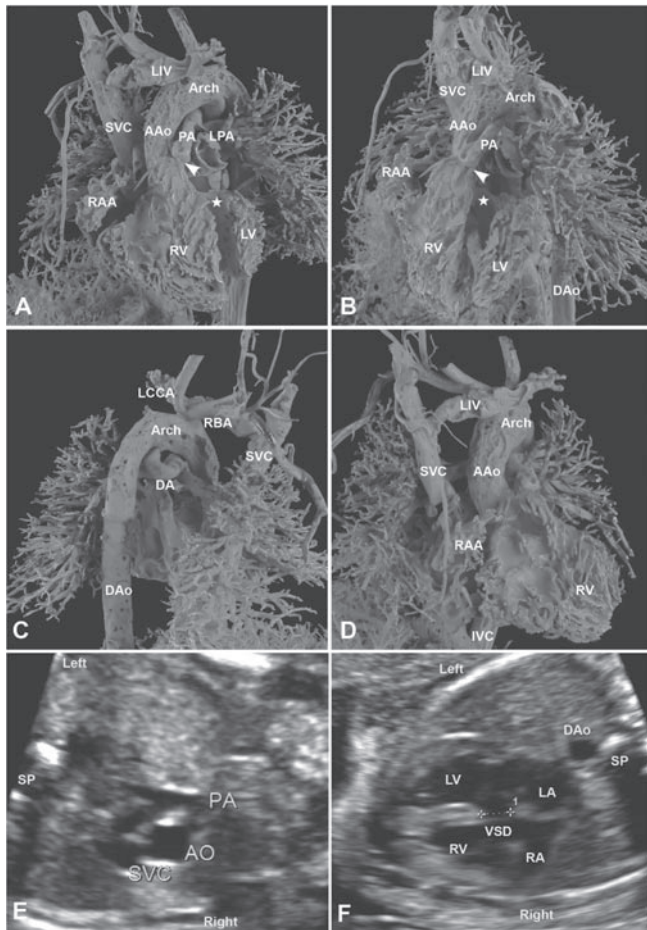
Cast demonstration of a fetus with hypoplastic left heart syndrome (HLHS), double outlet right ventricle (DORV), pulmonary valve atresia (PVA), pulmonary artery stenosis (PAS), ventricular septal defect (VSD), etc. (case 10). (A) Left anterior 30° view: AAo and PA are both originated from RV. A disconnection between RV and PA indicates the pulmonary valve atresia (white arrowhead). (B) Left anterior 45° view: Pulmonary trunk and left/right pulmonary artery are narrowed. An abnormal connection between RV and hypoplastic LV suggests a ventricular septal defect (white asterisk). (C) Right posterior 45° view: A tortuous DA connects PA and DAo. RBA and LCCA have a common trunk in the initial segment. (D) Right side view: Dilated AO anomalously originated from RV. (E) Prenatal echocardiography showed pulmonary stenosis. (F) A large VSD was showed in the prenatal sonography. AAo, ascending aorta; Arch: aortic arch; DAo, descending aorta; MPA, main pulmonary artery; LPA, left pulmonary artery; DA, ductus arteriosus; SVC, superior vena cava; IVC, inferior vena cava; LIV, left innominate vein; LV, left ventricle; RV, right ventricle; LAA, left atrial appendage; RAA, right atrial appendage; LCCA, left common carotid artery; RBA, right brachiocephalic artery.
